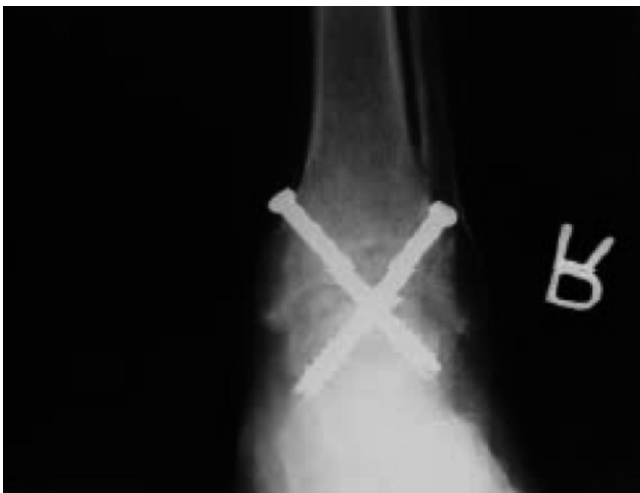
Anterior-posterior ankle weightbearing x-ray, 6 months post operative film.
